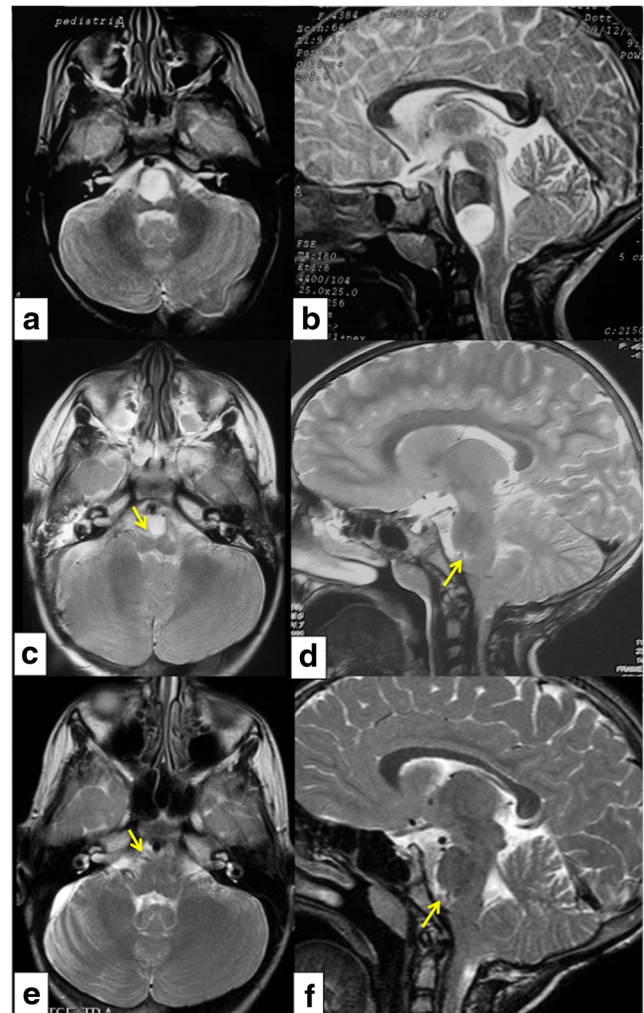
MRI study showing tumor recurrence on axial (a) and sagittal (b) T2-weighted images; postoperative MRI study showing the presence of the cystic-cisternal shunt (yellow arrow), with complete relief of tumor bulk-related mass effect on axial (c) and sagittal (d) T2-weighted images; MRI study, performed at last FU, showing the persistence of the cyst-cisternal shunt (yellow arrow) without disease progression on axial (e) and sagittal (f) T2-weighted images
